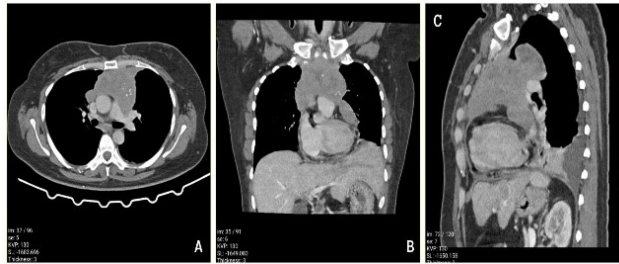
Computed tomography of the chest, A transverse view, B coronal view, C sagittal view, heterodense mass (100 mm × 67 mm) is seen in the superior, anterior, and middle mediastinum with invasion to pericardial and mediastinal pleura and foci of calcification
